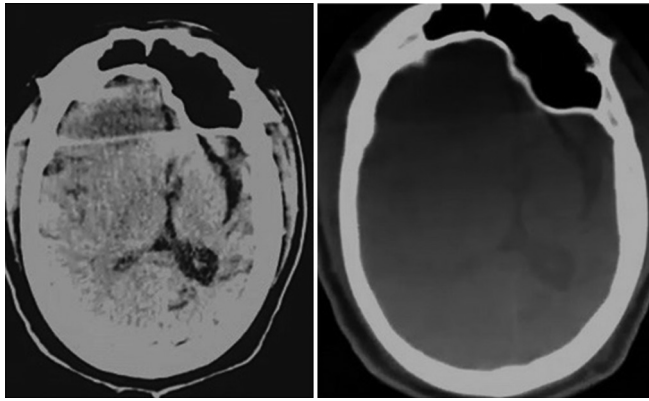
Axial non-contrast computed tomography head (brain and bone window). *Images showing the left cerebral hemispheric cortical atrophy dilation of lateral ventricle with left-sided calvarial thickening and the left side hyperpneumatization of the left frontal sinus
